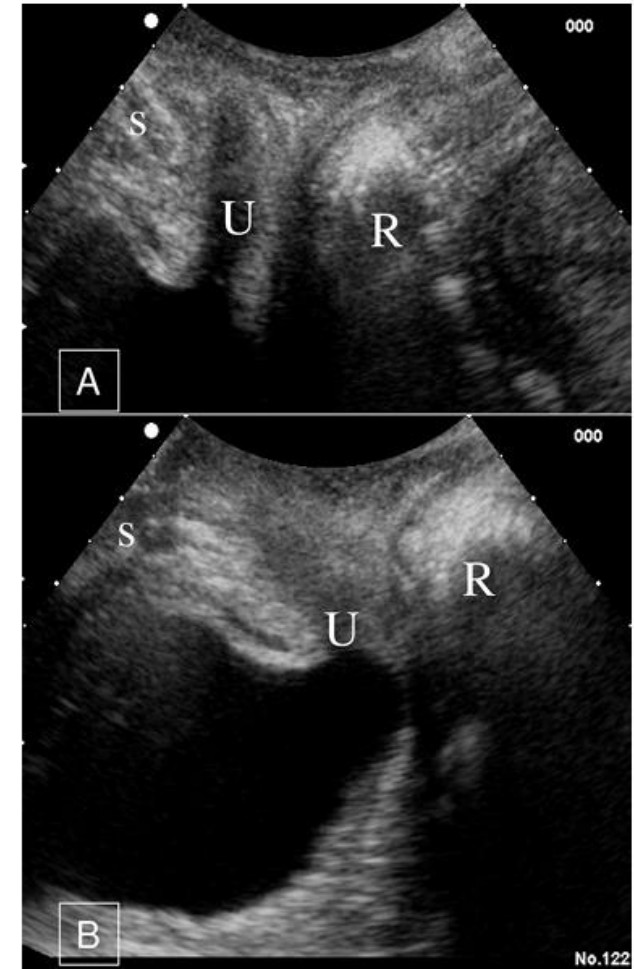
Photographs of sagittal plane taken with ultrasound probe on urethral meatus. S = symphysis; U = urethra; R = rectum. (A) Situation at rest. (B) Paradoxical reaction during contraction of pelvic floor muscles, showing important backward displacement of urethra and bladder neck, widening of bladder neck, and shortening of urethra.
